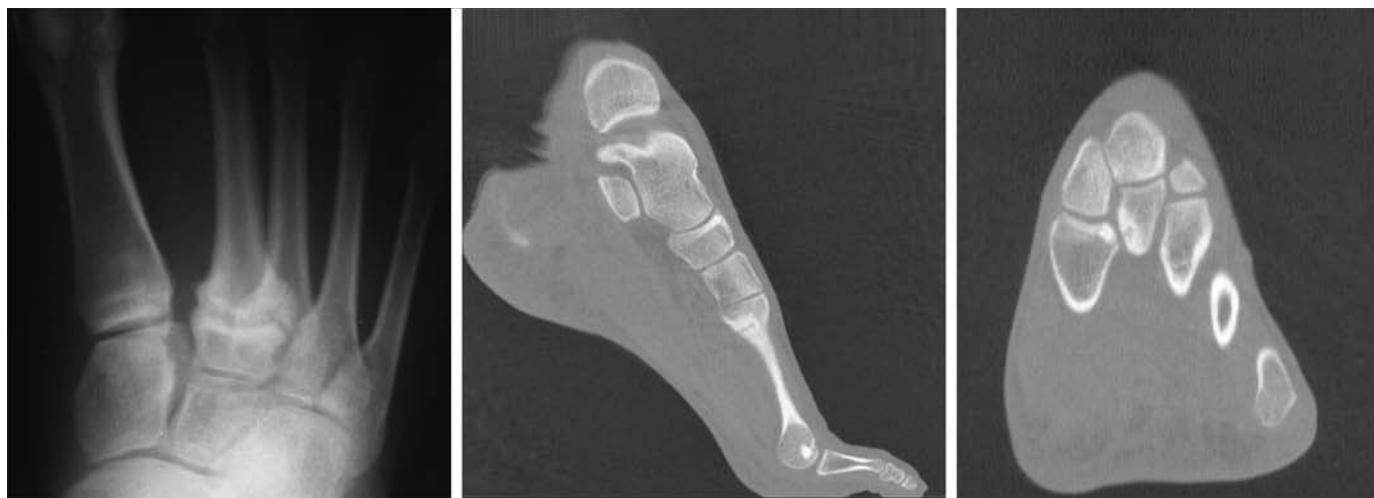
Stress Fracture of the Base of the Second Metatarsal in Dancers. Radiographic anterior-posterior view and computed tomography scan, sagittal and transverse plane views demonstrating the transverse fracture line.
